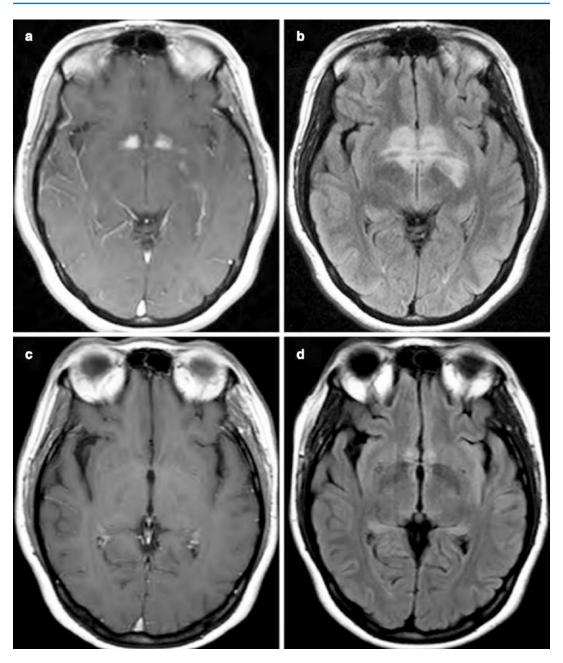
MRI of the brain from a 33-year-old female with recurrence squamous cell carcinoma of the cervix and anti-Ma2 antibodies. Postgadolinium T1 (a) and fluid-attenuated inversion recovery (FLAIR) (b) sequences obtained upon presentation. Postgadolinium T1
